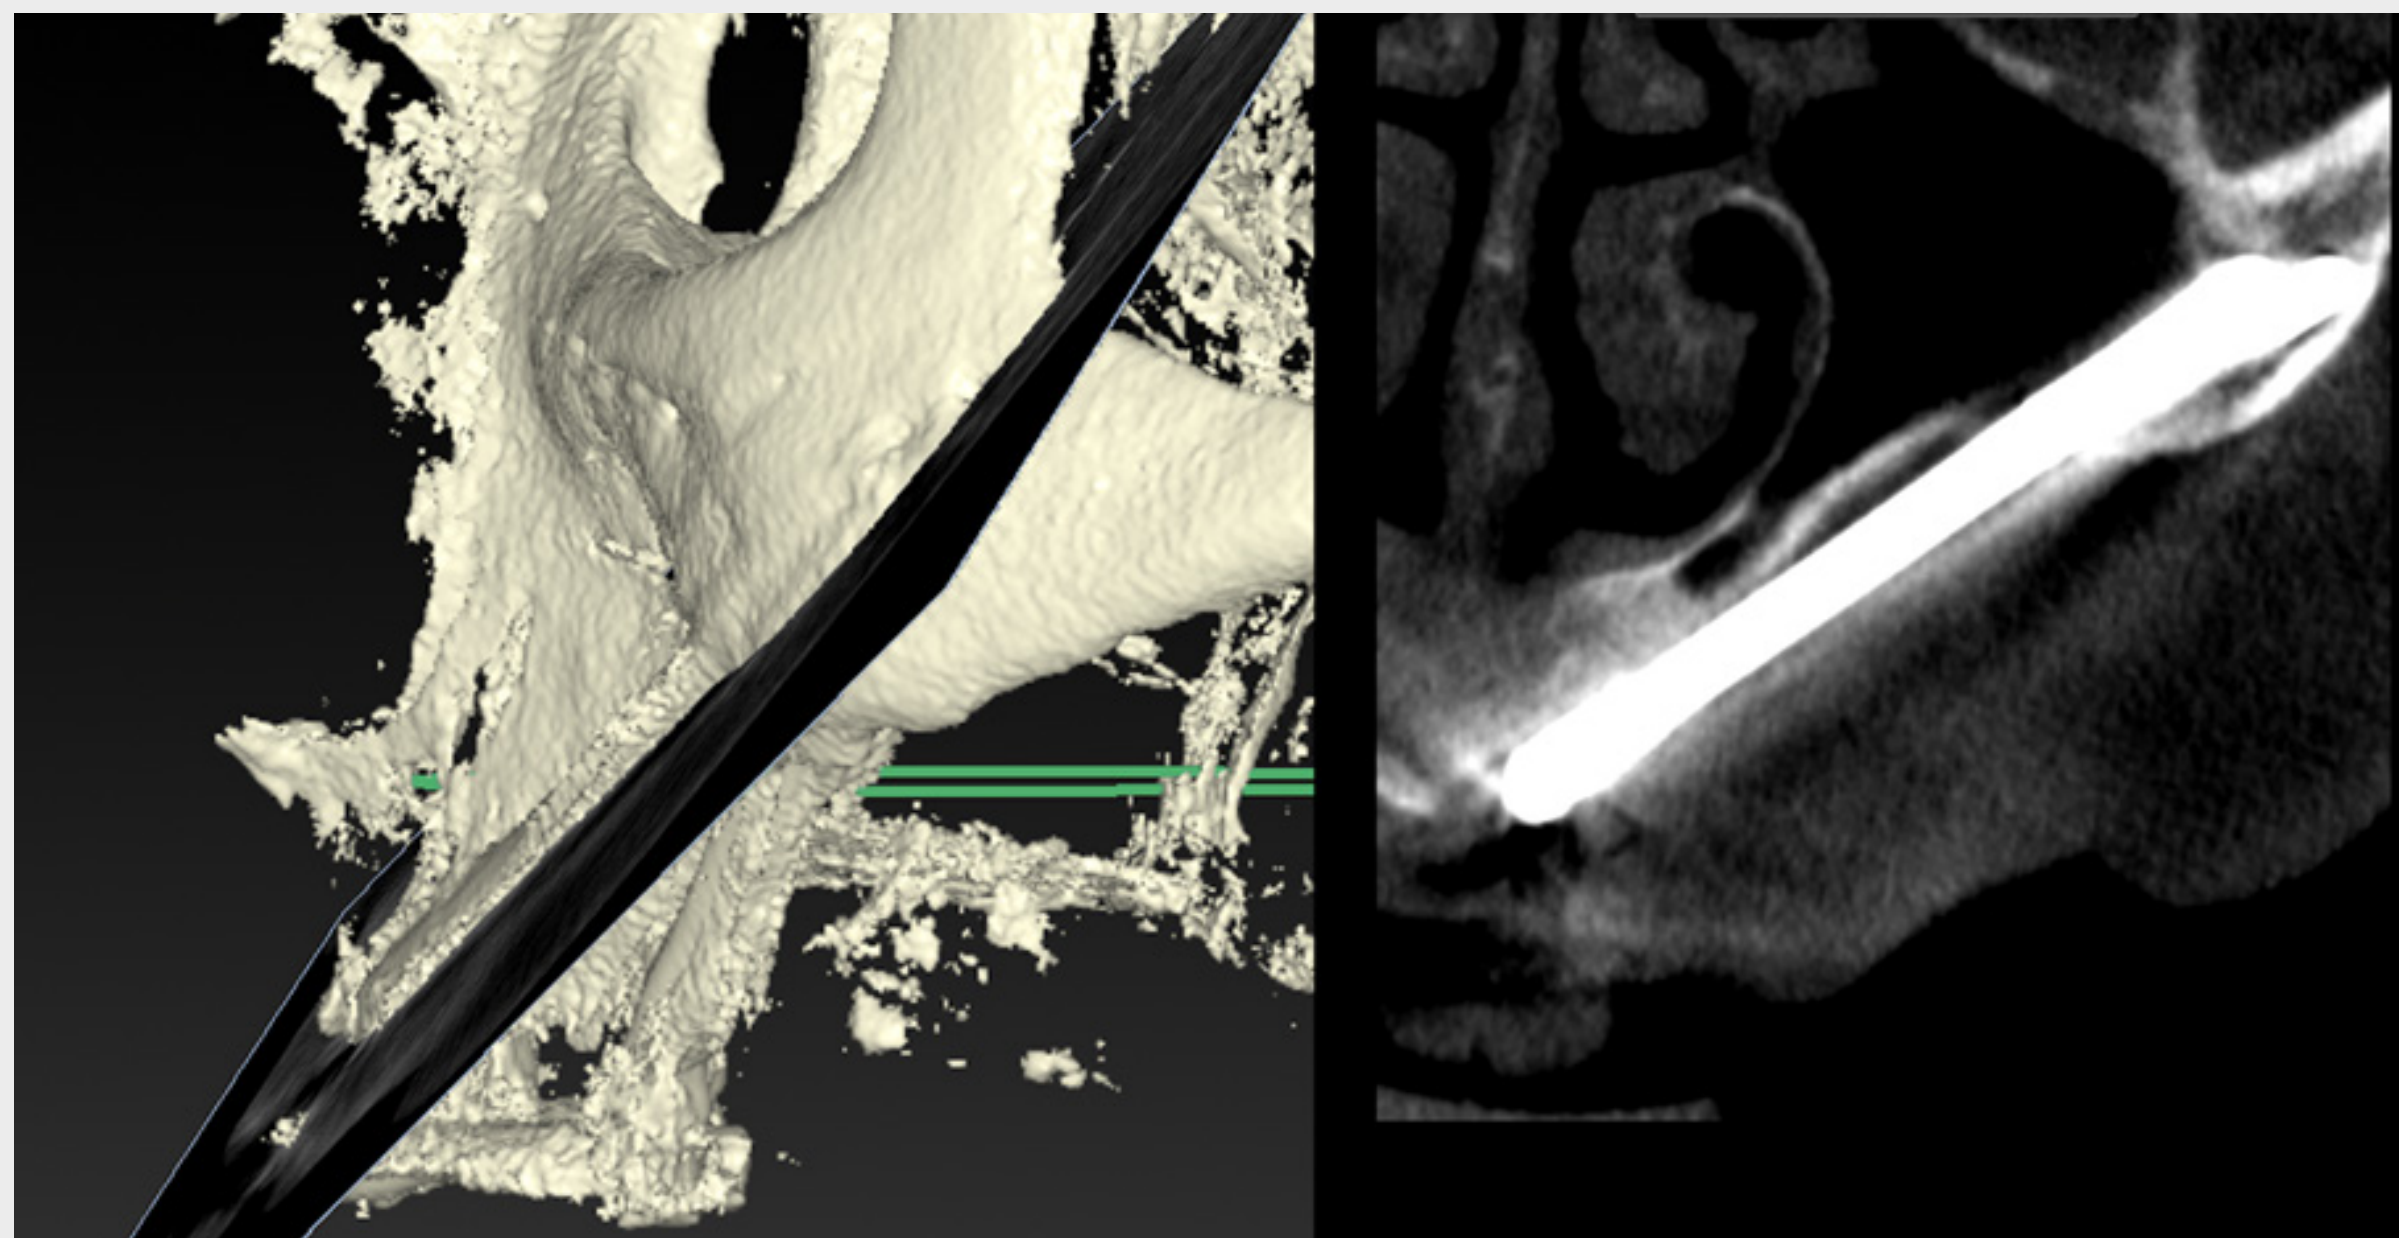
CBCT cut through the anterior left implant (ZAGA™ Type 3 - Straumann® Zygomatic implant, ZAGA™Round,) showing the state of the maxillary sinus after one year. Compare with the pre-surgery status shown in figure 4c.
